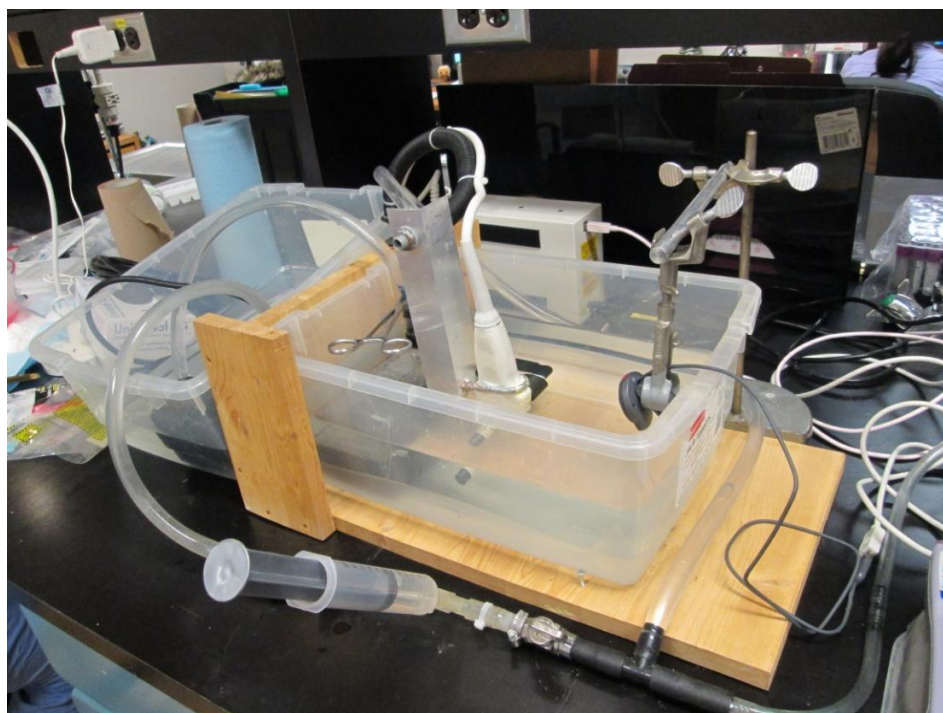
The replacement material was mounted as a tube in the pressurization testing equipment, including a syringe for pressure control (foreground), an ultrasound probe for measurement of radial dimensions (center), a webcam for measurement of longitudinal extension (right), and a manometer (almost completely outside of view, bottom right)
